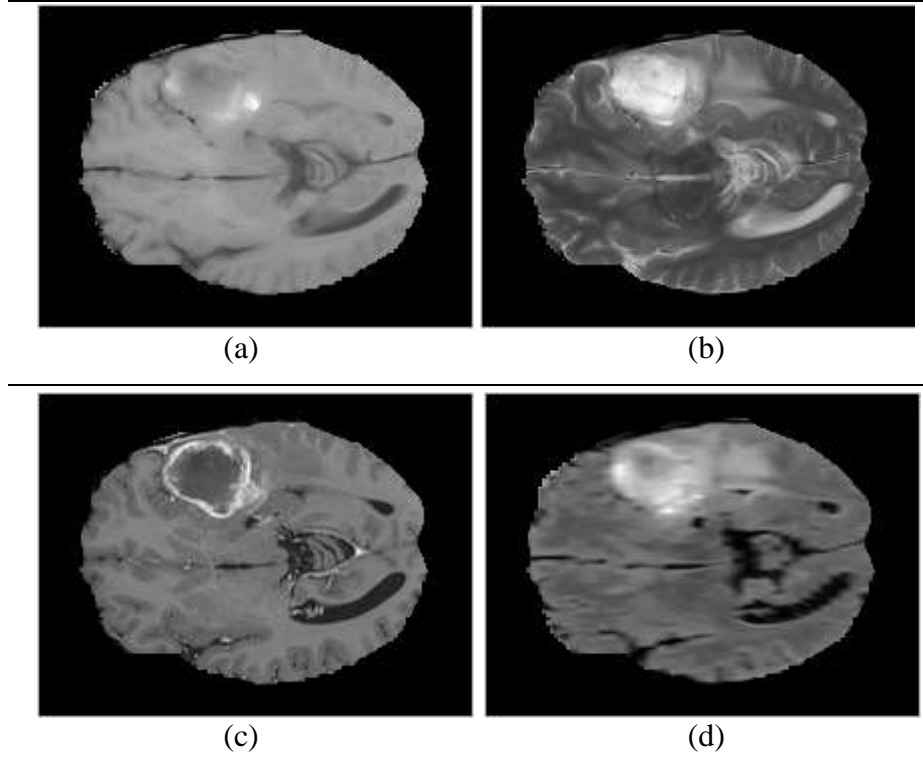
Brain multi-modality MRI; (a) T1, (b) T2, (c) T1C, (d) FLAIR.
